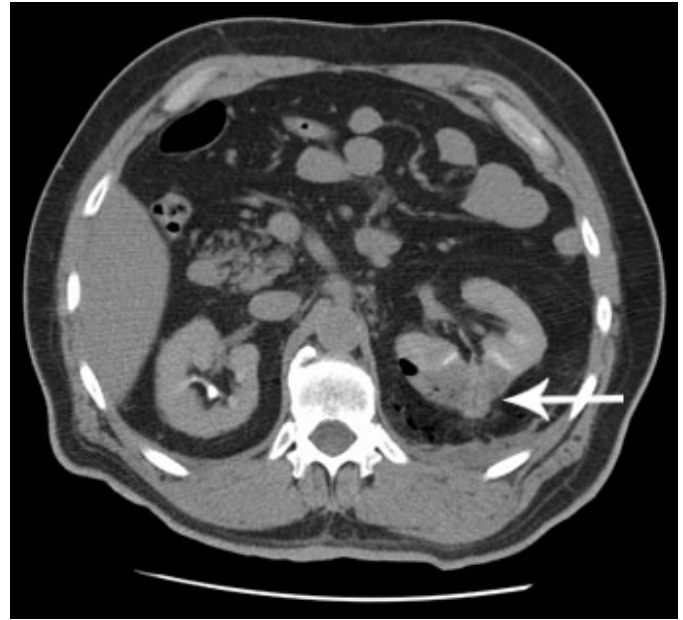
Axial CT immediately following ablation shows tumor shrinkage and a non-enhanced wedge shaped area consistent with ablated bed. No complications were identified.
